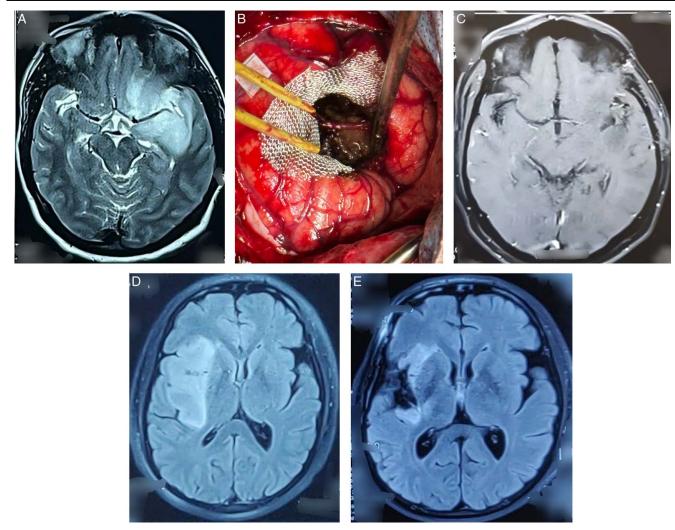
A: Preoperative T2 MRI image of left insular glioma. B: Peroperative resection of glioma (transopercular) with preservation of MCA branches. C: Postoperative MRI of insular glioma. D: Preoperative FLAIR image of right insular glioma. E: Postoperative FLAIR image of resected glioma.
